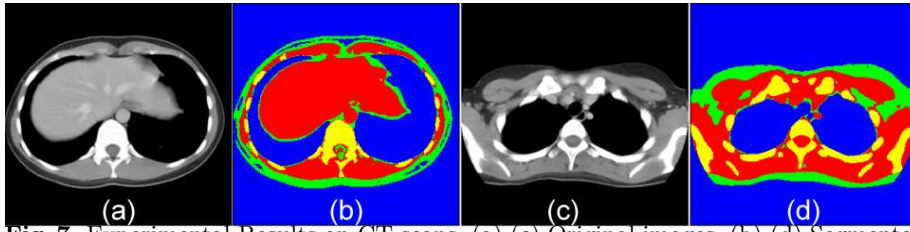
Experimental Results on CT scans. (a) (c) Original images. (b) (d) Segmented images.
